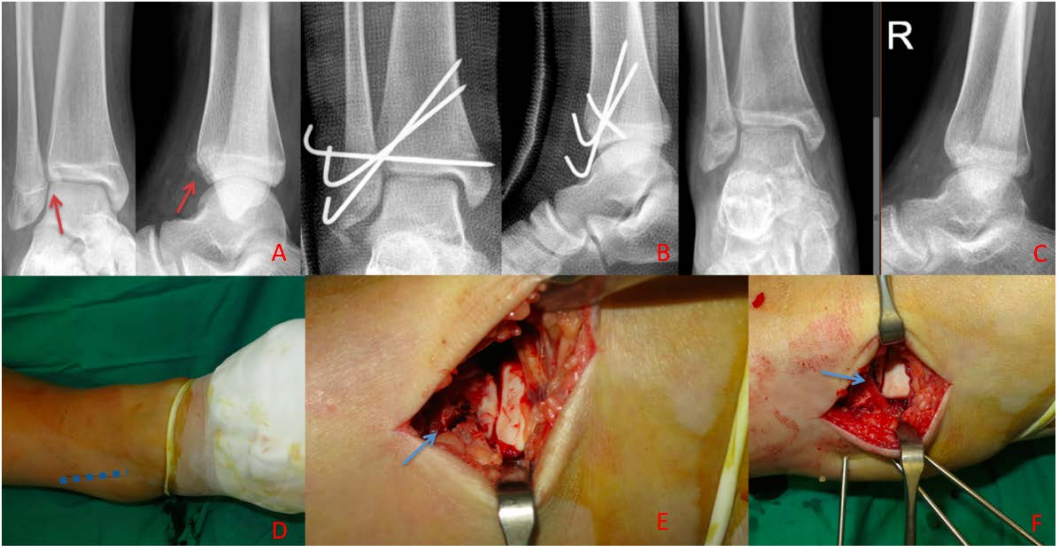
(A) X-ray showing tillaux fracture ( red arrow ). (B) Post-operative x-ray with percutaneous wire for 1 months and casting for 2 months. (C) Post-operative 6 months x-ray showing good fracture healing with no step off and no signs of arthritic changes. (D) Intraoperative picture showing 3 cm incision with antero-lateral approach. (E) Intraoperative picture showing displaced tillaux fracture. (F) Intraoperative picture showing anatomical reduction with intact joint line achieved (blue arrow) with three 2.0 mm percutaneous wires.
